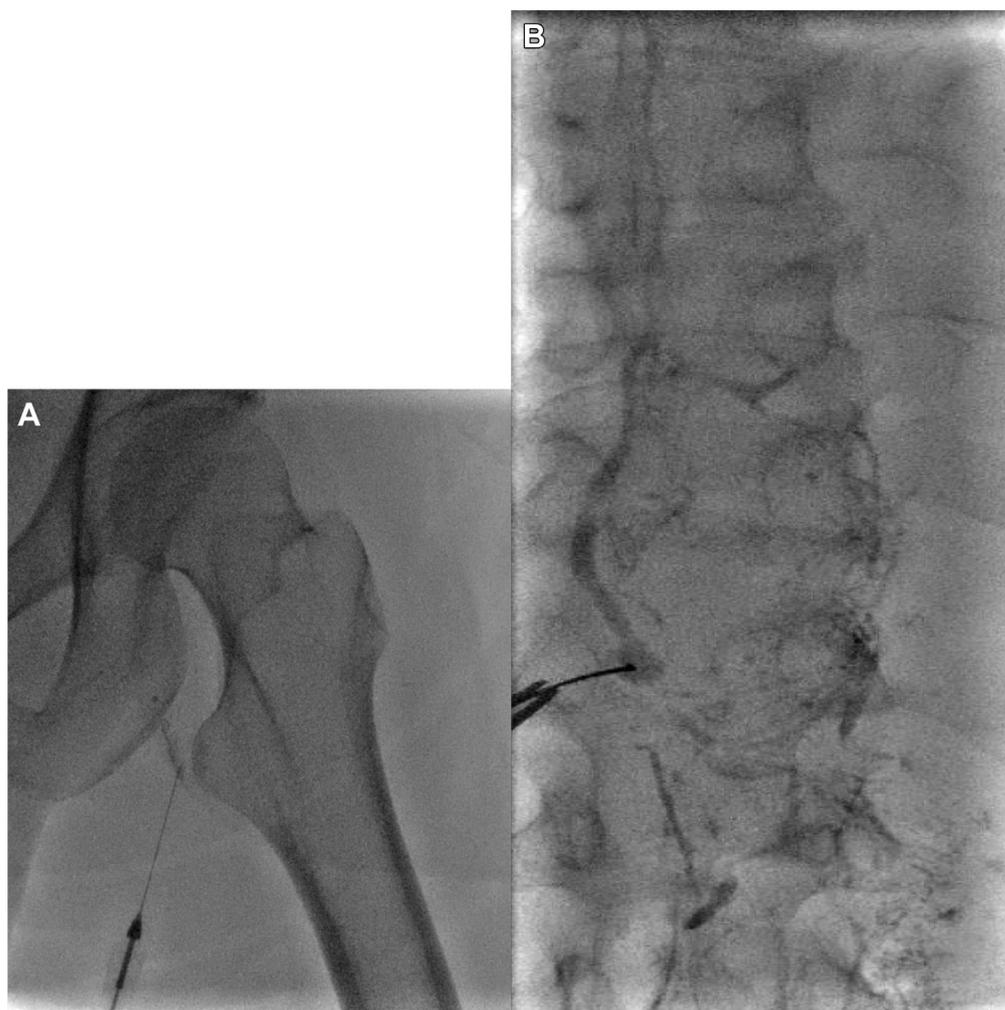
The thoracic duct (TD) was accessed by standard technique with lipiodol lymphangiography. A, Ultrasound guidance of left inguinal lymph node puncture was performed with a 25-gauge needle and injection of lipiodol. B, Fluoroscopy-guided cisterna chyli puncture with a 21-gauge Chiba needle.
